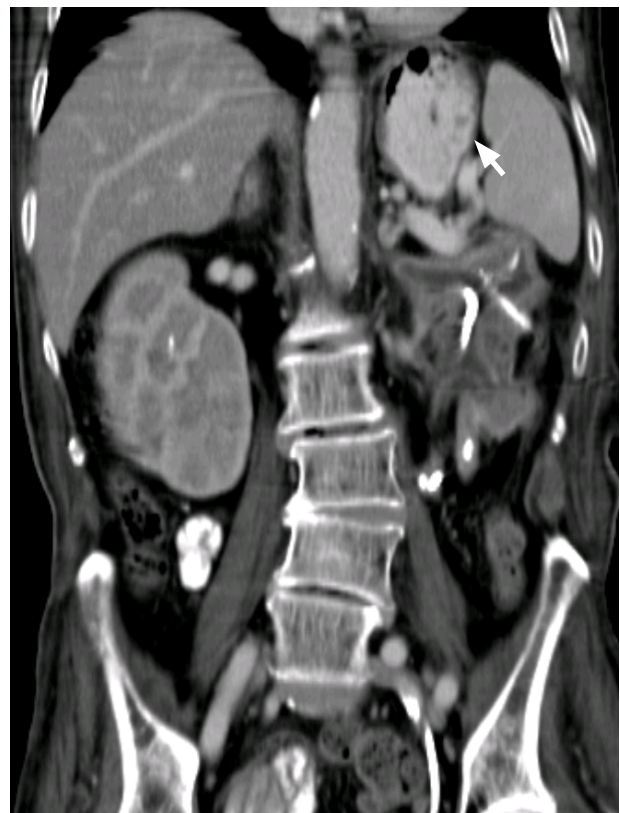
Follow-up computed tomography confirmed that the compression of the stomach caused by left giant hydronephrosis (arrow) resolved after drainage.
